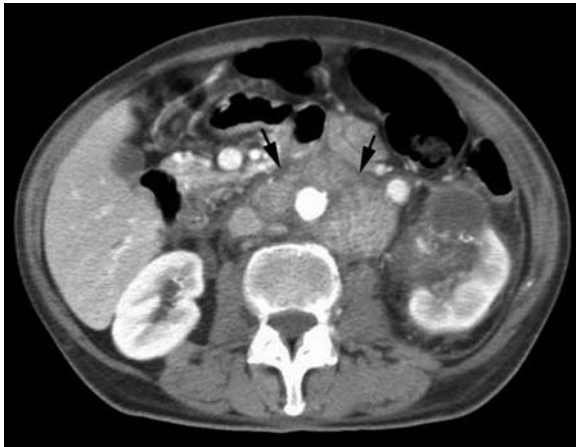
Lymph node metastasis in 67-year-old woman synchronous with renal cell carcinoma. Axial contrast-enhanced CT scan shows large heterogeneous enhancing retroperitoneal and para-aortic lymph node mass (*arrows*) associated with a large heterogeneous hypodense anterior mass of the left kidney corresponding to cystic renal cell carcinoma.
